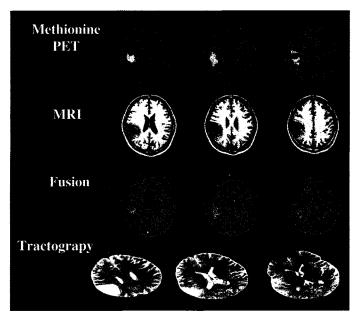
Positron emission tomography (PET) with L-[methyl-¹¹C]methionine and MR tractography of a patient with right parietal low-grade glioma. Methionine-PET images, corresponding MRIs, and the fusion images of MET-PET and MRI are shown in the top three rows and MR tractography, in the bottom row
